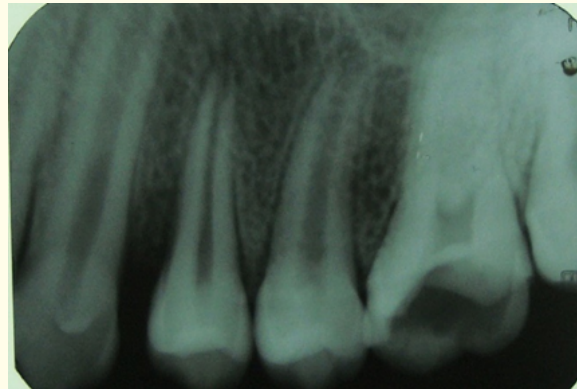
Intraoral radiograph depicting oral lesion.
